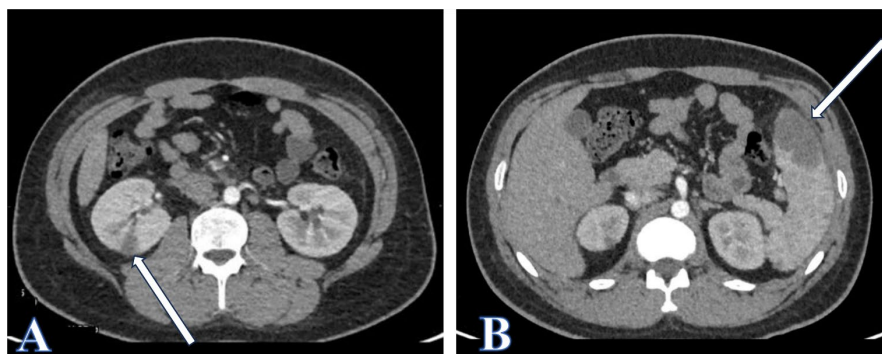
Axial view of CT scan of the abdomen showing infarctions (arrows) in: (A) right kidney and (B) in the spleen.
